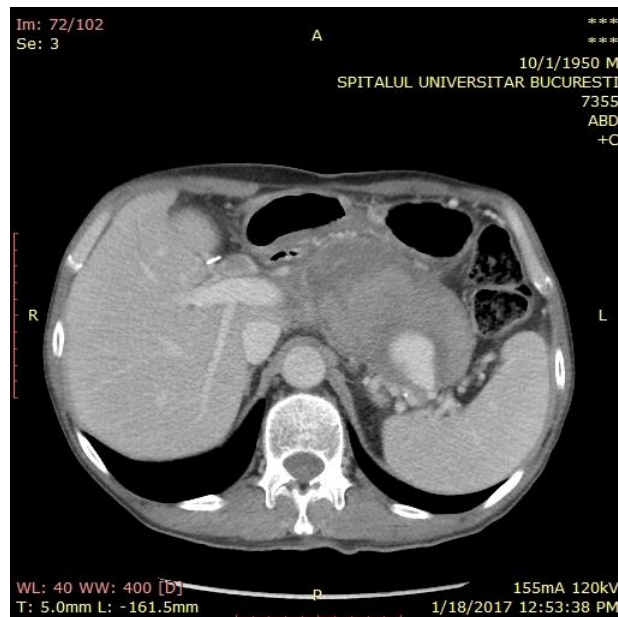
Contrast-enhanced CT scan axial section – venous phase. Inhomogenous pseudocyst to the body and tail of the pancreas; contrast is noted to the tail section of the pseudocyst
